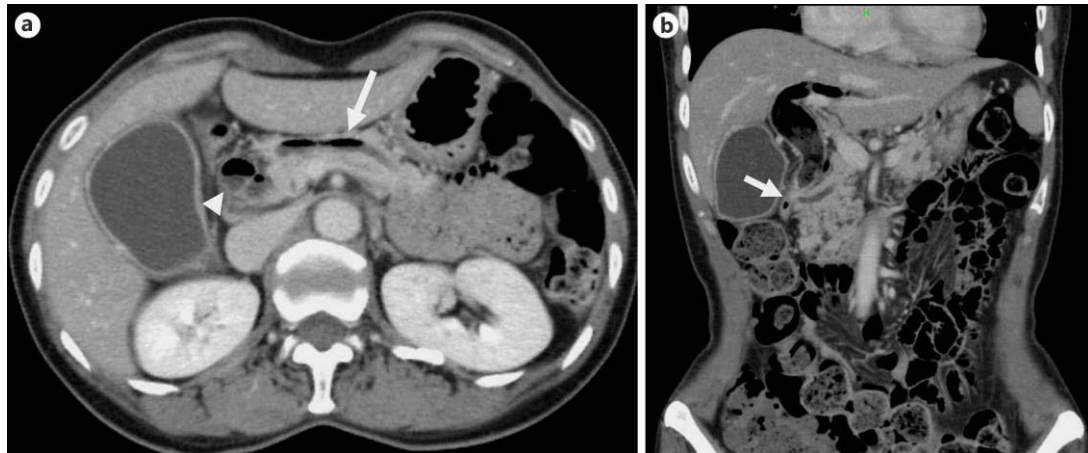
a Contrast computed tomography shows mild pancreatic duct dilation and air density in the pancreatic (arrow) and common bile ducts (arrowhead). b The common bile duct shows dilatation. Air density can be seen in the intrahepatic and extrahepatic bile ducts. Orifices of the pancreatic and bile ducts appear to be close to the duodenal bulb (arrow).
